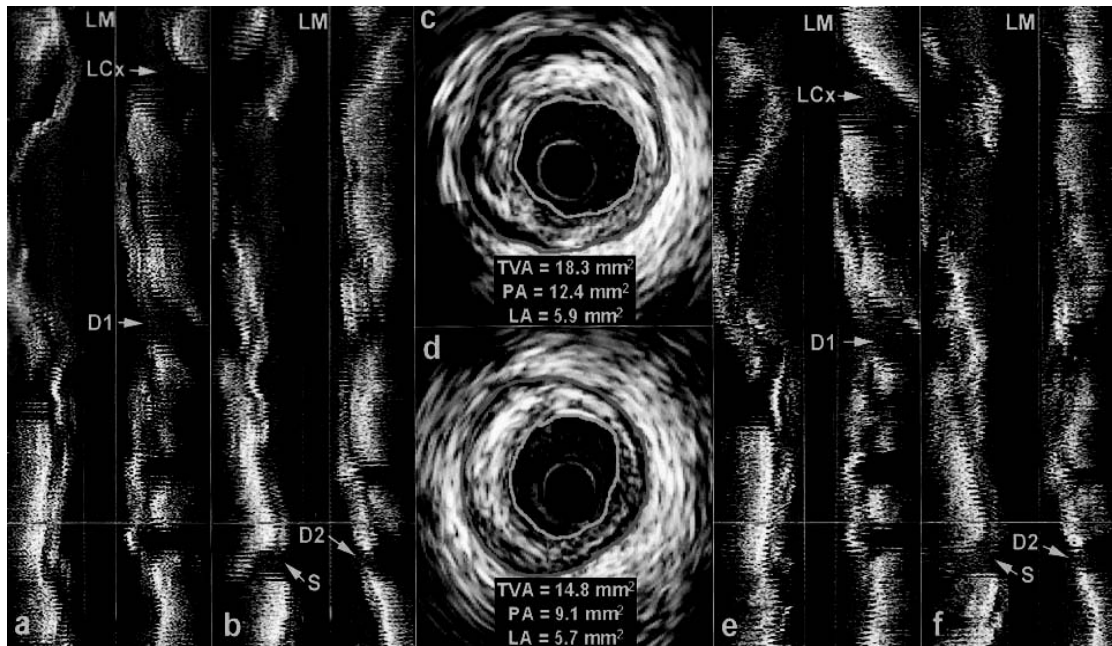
Left panels, Longitudinal intravascular ultrasound reconstruction of the LAD at 6 months follow-up, corresponding to the angiographic projection in Figure 1. The left main coronary artery (LM) is on top of the image and the distal LAD at the bottom. a, Slice showing the bifurcations with the left circumflex coronary artery (LCx) and the first diagonal branch (D1). b, Slice showing the bifurcations with the second diagonal (D2) and the septal (S) branches. There is a 60-degree difference between the planes of slices shown in panels a and b. Right panels, Longitudinal intravascular ultrasound reconstruction of the LAD at 3 years follow-up. Slice shown in panel e corresponds to that in panel a. Slice shown in panel f corresponds to that in panel b. Middle panel, Cross-sectional images corresponding to the site of the initial stenosis at baseline, just before the bifurcations of the LAD with the D2 and the septal branches, as indicated by the yellow and red horizontal lines at the longitudinal reconstructions shown in the lower half of the other panels, at 6 months (c) and 3 years (d). The red line delineates the external elastic membrane and the green line the lumen surface. Between 6 months and 3 years, a reduction in the total vessel area (TVA) can be observed (negative remodeling) with accompanying reduction in the plaque area (PA) (plaque regression). This results in an unchanged lumen area (LA) between 6 months and 3 years.
